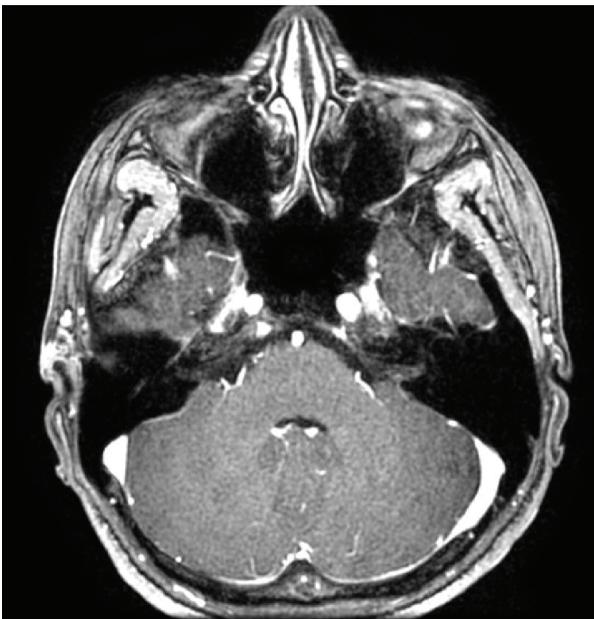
Axial T1-weighted MR images Temporal bone
